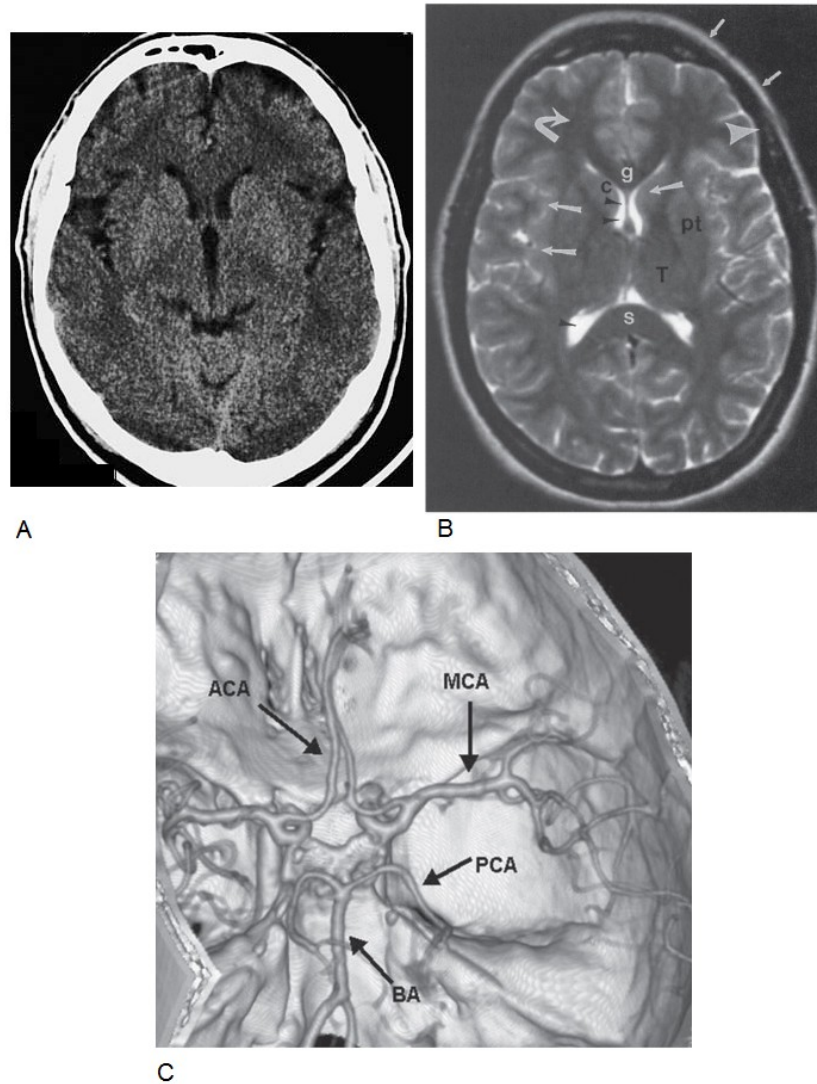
Normal brain images. A. Axial CT scan of the brain. Adapted from: Moeller TB, Reif E. *Normal Findings in CT and MRI*, 1st edition, page 7. B. Axial T2-weighted MRI of the brain. MRI provides a good assessment of brain structures with differences in signal intensity. C. CT angiogram of intracerebral arteries with 3-dimensional volume rendering (axial and slightly oblique view). Gray matter (large white arrows), white matter (curved white arrow), lateral ventricles (black arrowheads), fat (small white arrows), and cortical bone (large arrowheads) on different pulse sequences. Structures identified are the genu (g) and splenium (s), caudate head (c), putamen (pt), and thalamus (T). For B and C, images adapted from: Chen, Pope and Ott. *Basic Radiology*, 2nd edition, Chapter 12.
